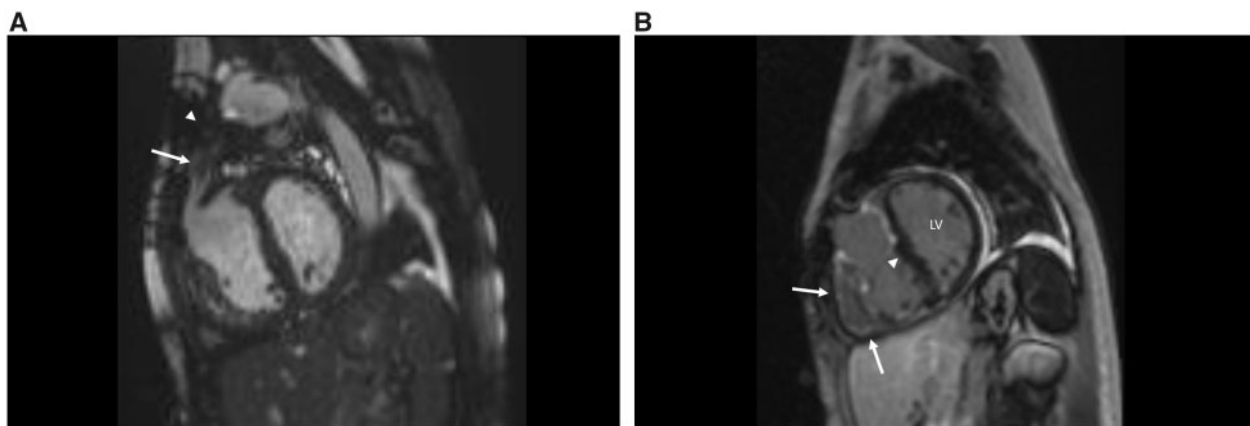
(A) Right ventricular outflow tract view from a cardiac magnetic resonance imaging scan showing the valved right ventricle to pulmonary artery conduit (arrow) with significant blooming artefact from the valve (arrowhead). (B) Short axis view from a cardiac magnetic resonance imaging scan showing late gadolinium enhancement of the right ventricular anterior (arrow) and inferior (arrow) wall. D-shaped left ventricle (LV) with flattening of the interventricular septum (arrowhead).
